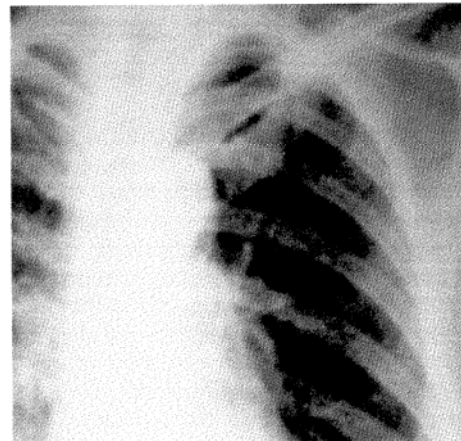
Chest radiograph at presentation with miliary mottling.
